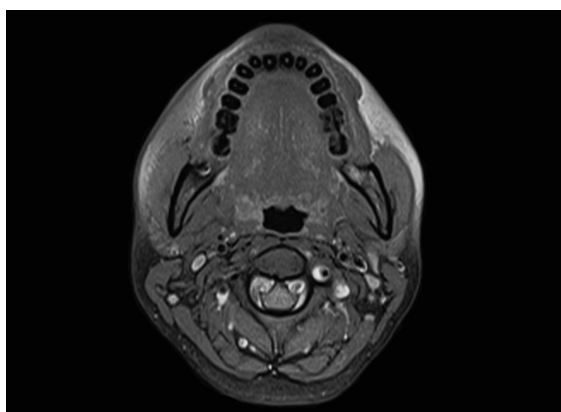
Brain magnetic resonance imaging scan showing left vertebral artery dissection
